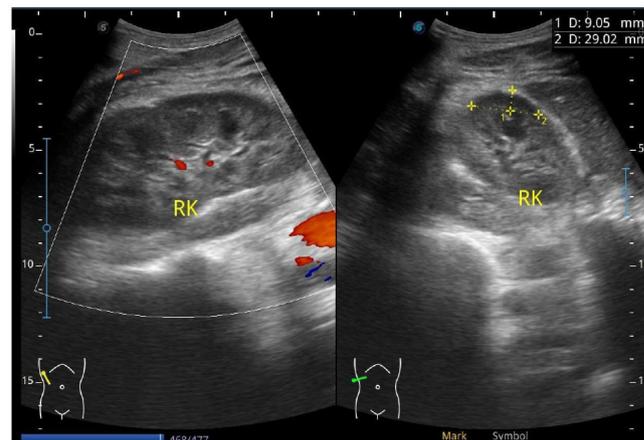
A sonographic picture of the right renal subcapsular hematoma $0.9 \times 2.9 \times 4.6$ cm shows a fluid-filled mass pressing on the renal parenchyma
